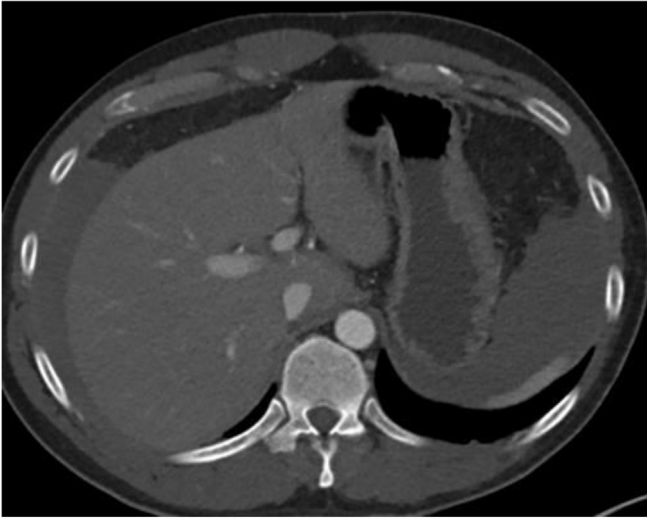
Contrast-enhanced computed tomography images showed a hematoma in the retropancreatic space and free fluid in the abdomen, layering above the liver.
